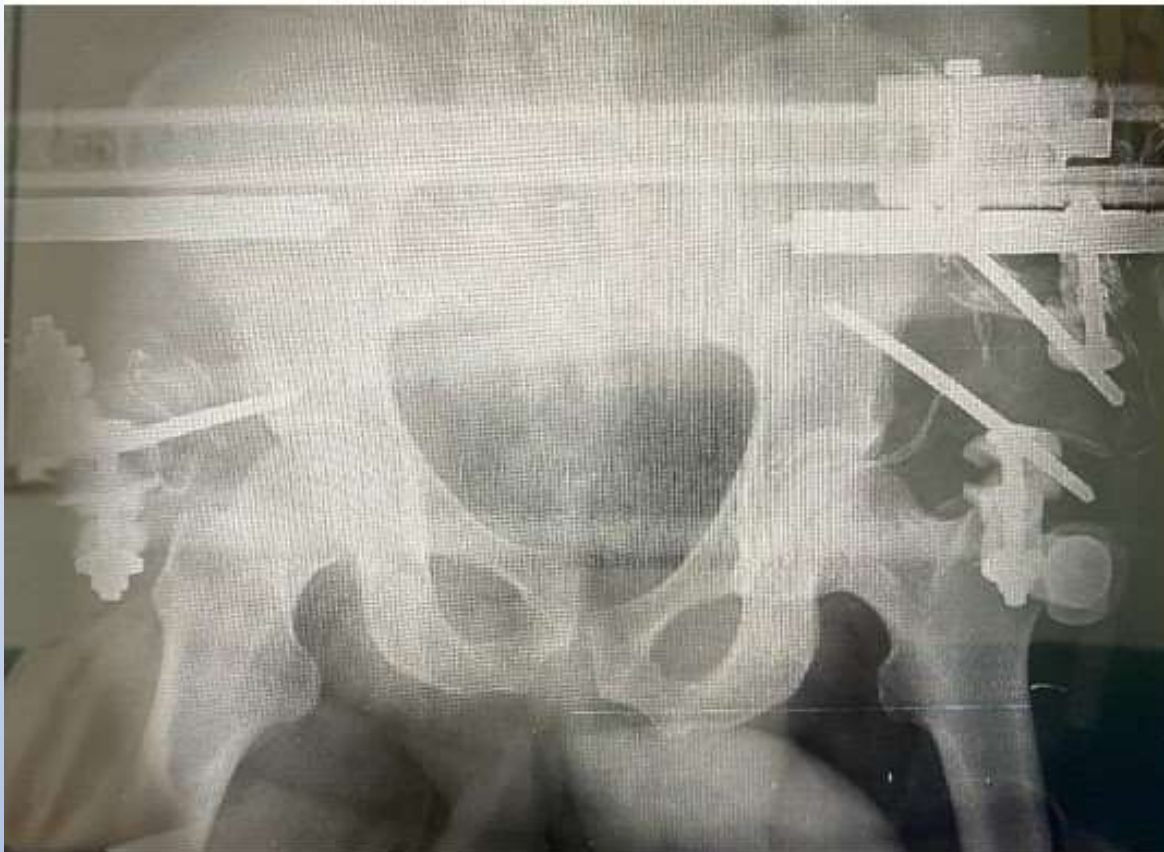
Case 3. Left side: Postoperatively x-ray with the C-clamp & the External fixator in positioning.
